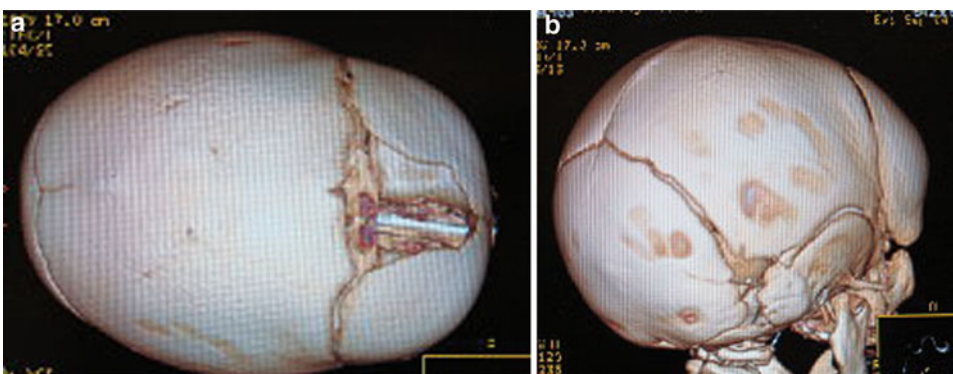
(a, b) Three-dimensional CT reconstructions from the same patient shows dolichocephalic skull resulting from premature fusion of the sagittal suture (a) and sagittal ridge (b)
